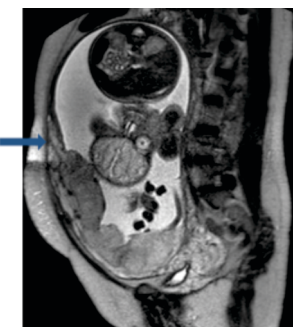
Sagittal T2 W MR image shows complete placenta previa with focal interruption of myometrium and extension of placenta upto the serosa at the level of umbilicus(blue arrow).
